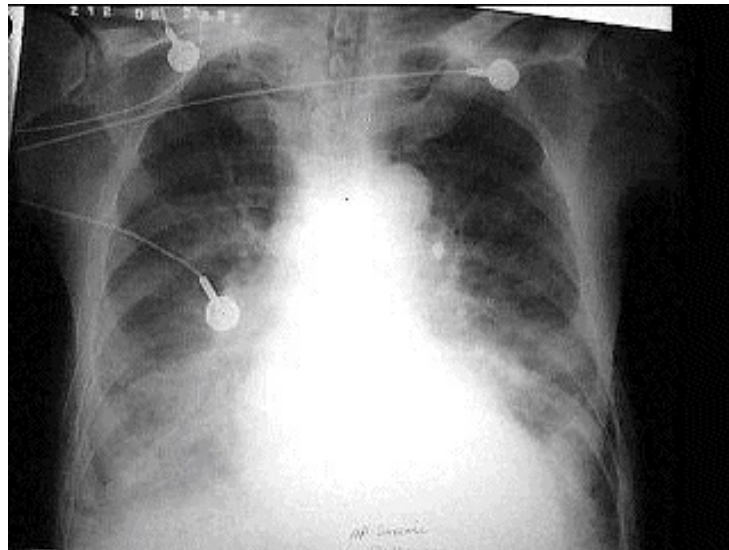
Chest X-ray Demonstrating Acute Exacerbation of Congestive Heart Failure
